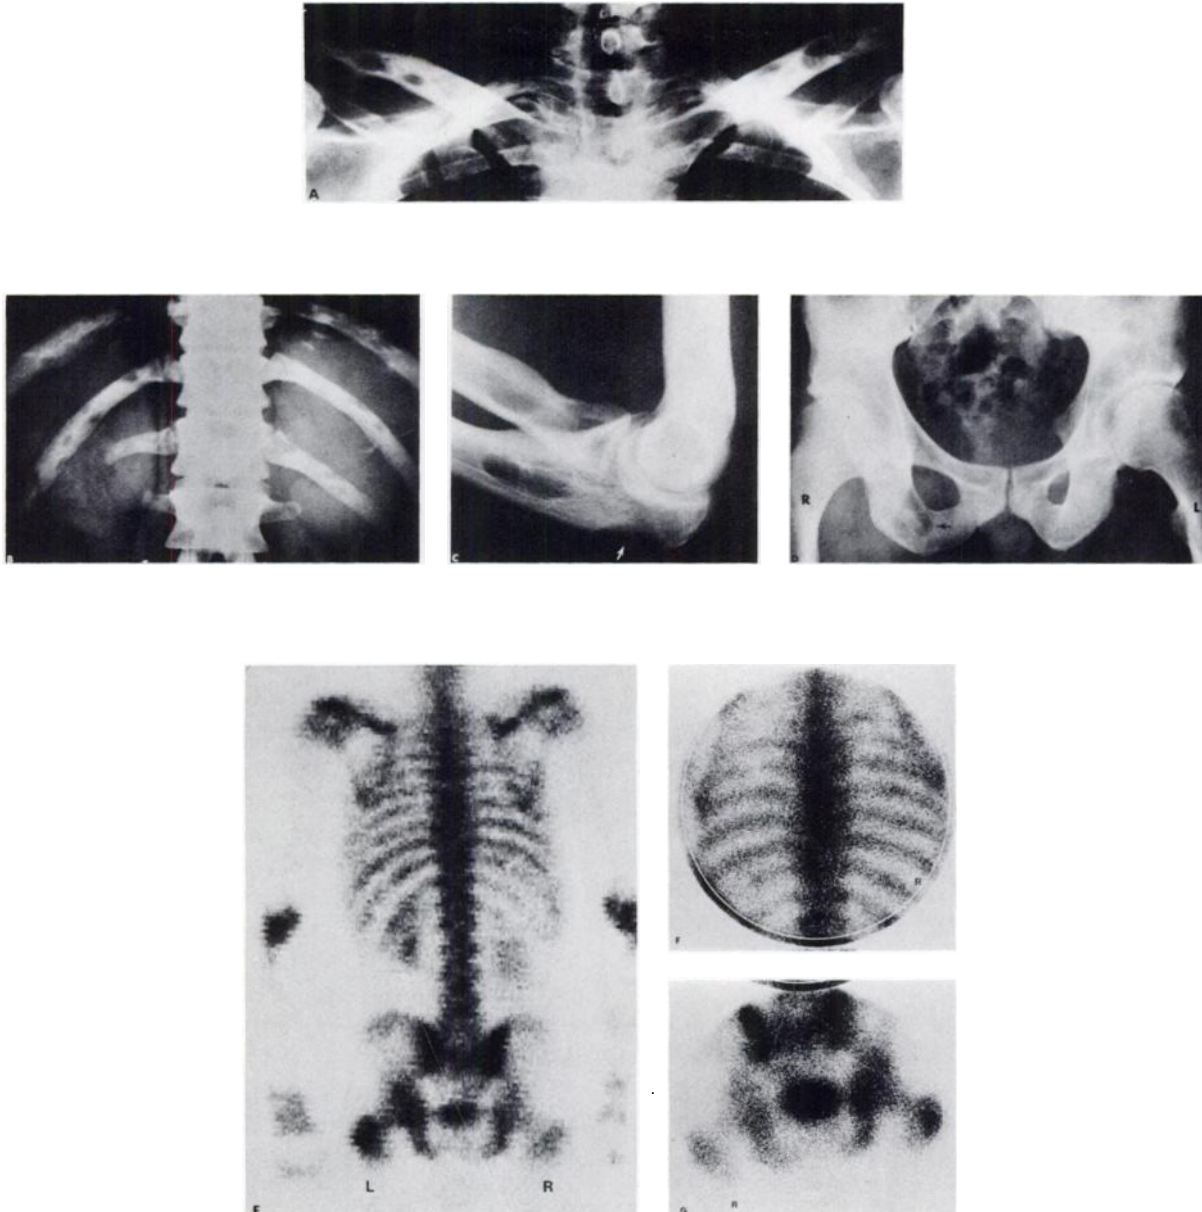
Case 1. (A–D) Note multiple lytic lesions involving pelvis, radius, ulna, ribs, proximal left femur, and clavicles. Lesions are predominantly lytic, with no periosteal new-bone formation and only minimal sclerosis. Note particularly involvement of bony prominences, i.e., olecranon and ischial tuberosity (arrows). (L = left, R = right.) (E–G) Bone scan reveals several areas of increased Tc-PPi uptake (i.e., left ischium, left trochanter, and left hip) but in general is less striking than corresponding radiographs. On close inspection it is noted that clavicles also show increased uptake and ribs have mottled appearance due to diffuse involvement.
